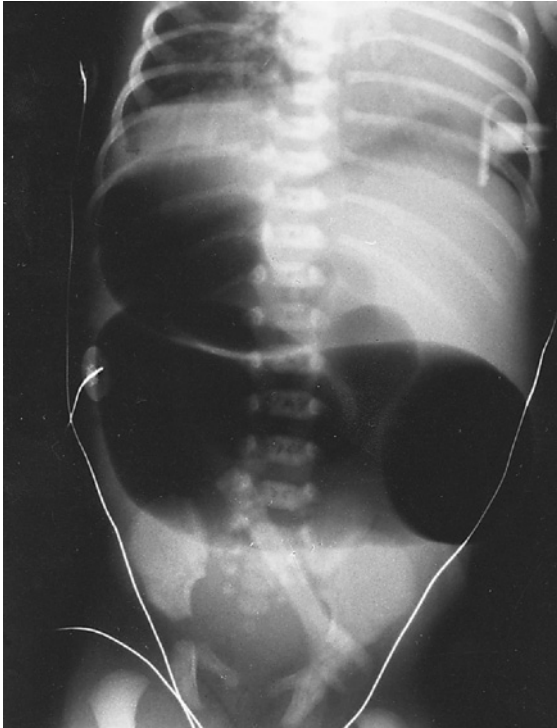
Intestinal atresia. Abdominal x-ray shows an obstruction of the jejunum. The neonate also has *situs inversus*.
